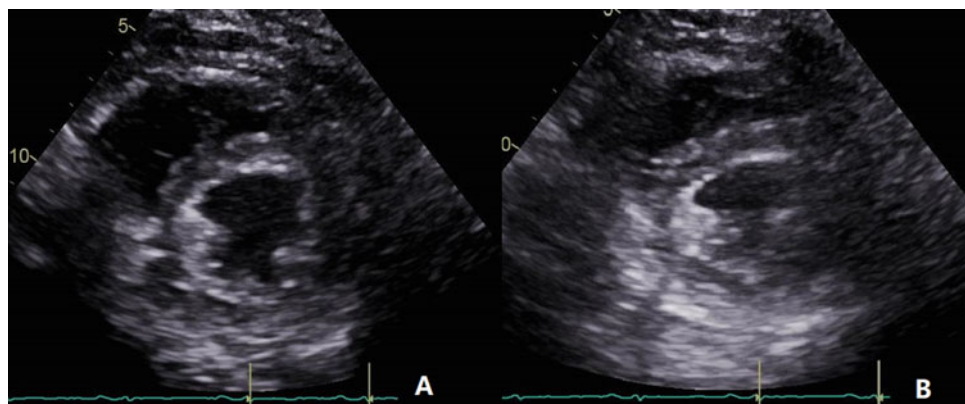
Still figures from Video 21.4. a and b are parasternal short-axis views of the left ventricle. a shows the interventricular septum during expiration at end-diastole and b shows the interventricular septum during inspiration at end-diastole (see Video 21.4)
